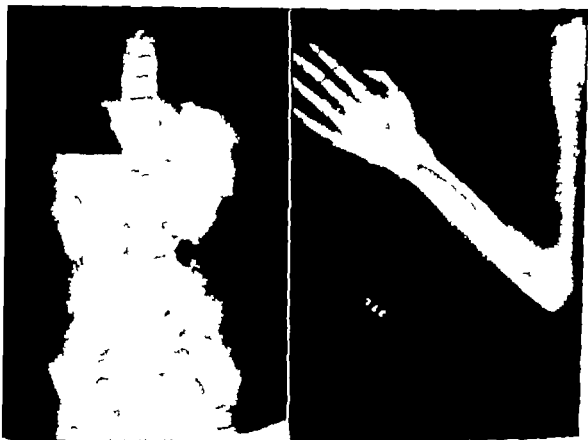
The roentgenogram of patient with arachnodaelyia. There is unusual length to long bones and phalanges and a mild scoliosis.
